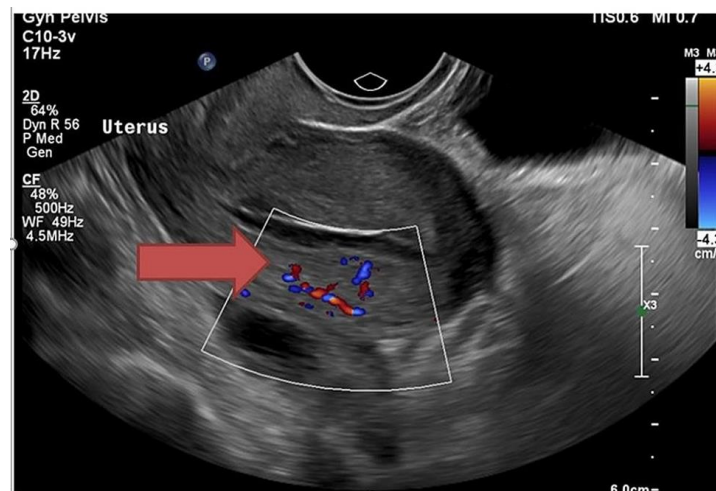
Transvaginal greyscale sonography showing myometrium having remarkable tortuous, tubular anechoic spaces in the anterior uterine wall (Red arrow). B: Transvaginal ultrasound with color doppler imaging showing high flow and low resistance vascularity in tortuous, tubular anechoic spaces within the anterior uterine myometrium (blue arrow).
